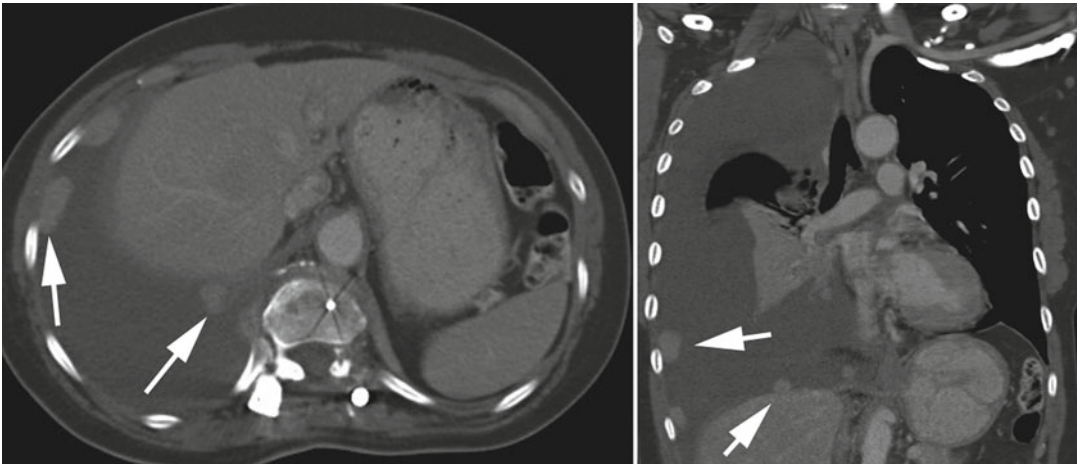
Pleural metastases. Axial and coronal CT images reveal large right pleural effusion with enhancing pleural nodules (arrows)
